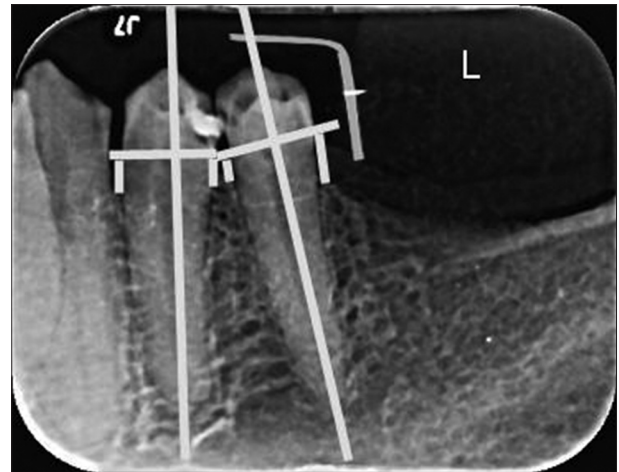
Digital periapical X-ray with reference lines and points for measuring left abutments alveolar bone height at 6 months follow-up
